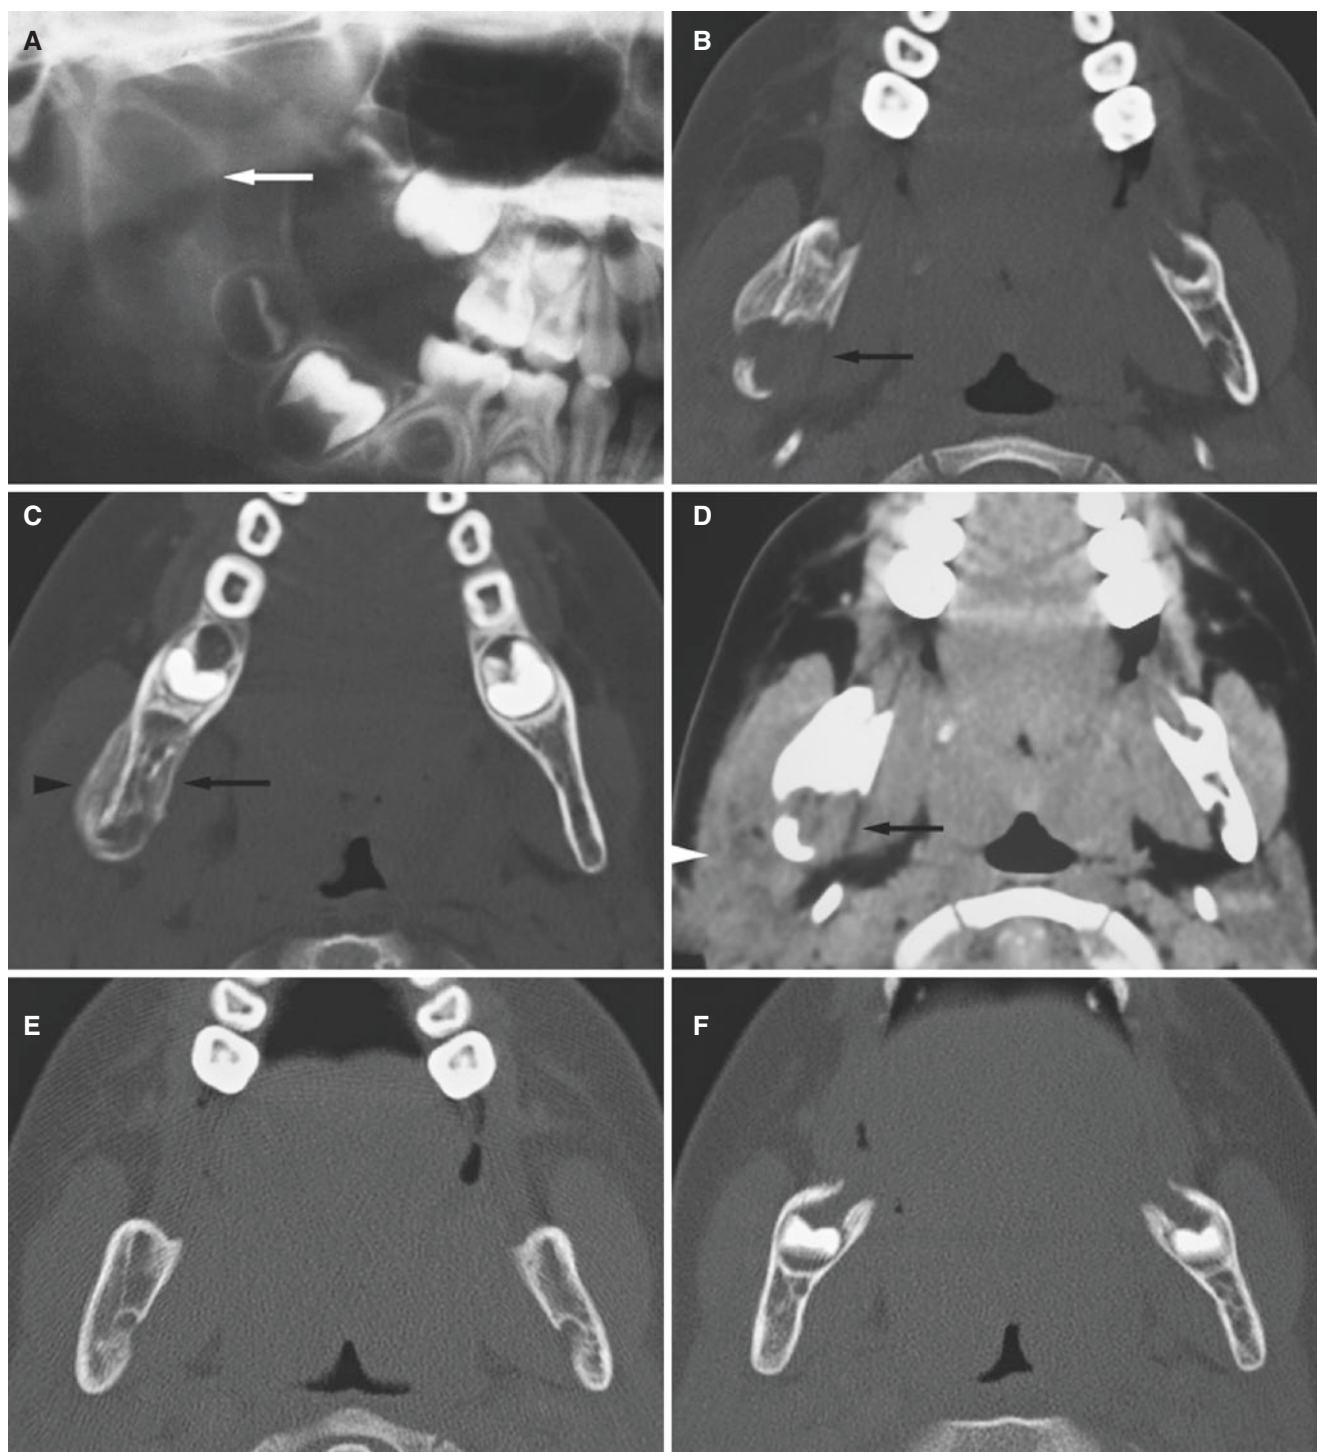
Langerhans cell histiocytosis, mandible; 4-year-old male with pain and swelling in the right cheek and jaw (ramus). (A) Panoramic view shows rather well-defined radiolucency (*arrow*). (B) Axial CT image shows punched-out bone destruction at the level of mandibular foramina (*arrow*). (C) Axial CT image shows onion skin periosteal reaction lingually (*arrow*) and buccally (*arrowhead*). (D) Axial CT image, soft-tissue window, shows well-defined soft-tissue
